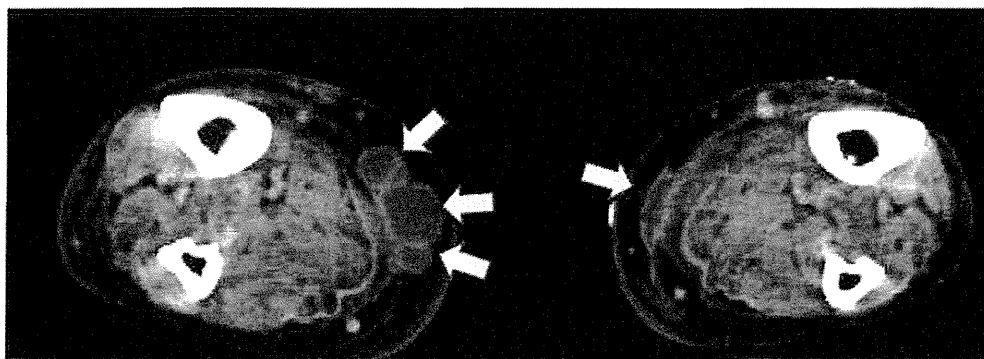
T1-weighted magnetic resonance image showing a well-demarcated collection of fluid in the soft tissue of both lower legs (arrows), suggesting a subcutaneous abscess.
